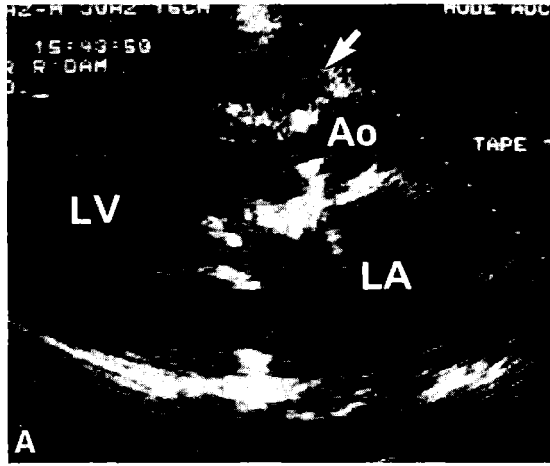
Precordial (A) and transesophageal (B, C) systolic still frames from a patient with triple valve replacement and infective endocarditis (Table 3, case 12). A, A mycotic aneurysm (arrow) anterior to the aortic Björk-Shiley prosthesis was characterized by an echolucent area. B, Posterior to the aortic prosthesis a mycotic aneurysm was observed (asterisk). C, There were additional flail leaflets (arrow) of the Hancock mitral prosthesis. Ao = aorta; LA = left atrium; LV = left ventricle.
